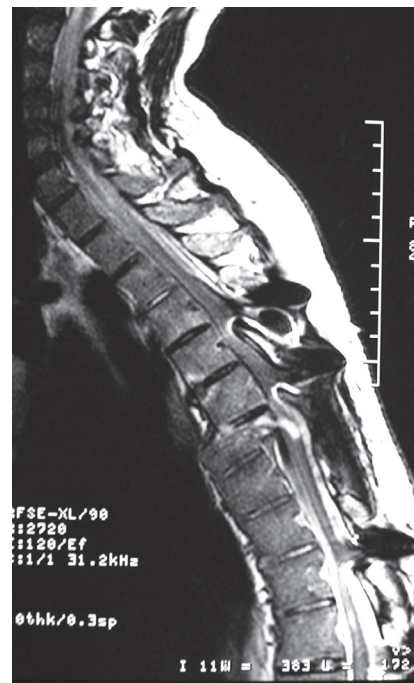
Sagittal T2 magnetic resonance imaging of dorso-lumbar spine at one year post-trauma.
